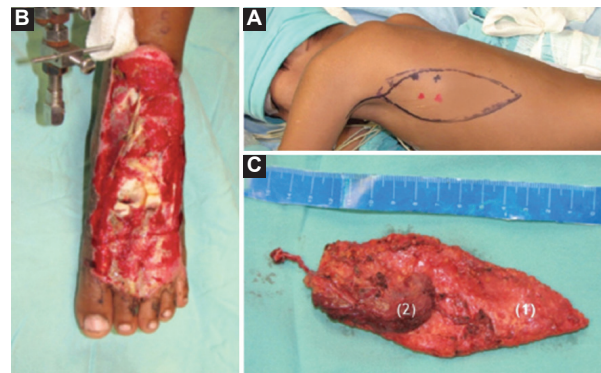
Marking, area of exposed tissue and flap in an 8-year-old male patient with an injury to the left foot dorsum resulting from a car accident. A: perforating arteries identification and marking by portable Doppler in the path of the thoracodorsal artery descending branch. B: exposed-tissue area on left foot dorsum, with extensor tendons loss. C: flap with skin island (1) and a portion of latissimus dorsi muscle (2).
